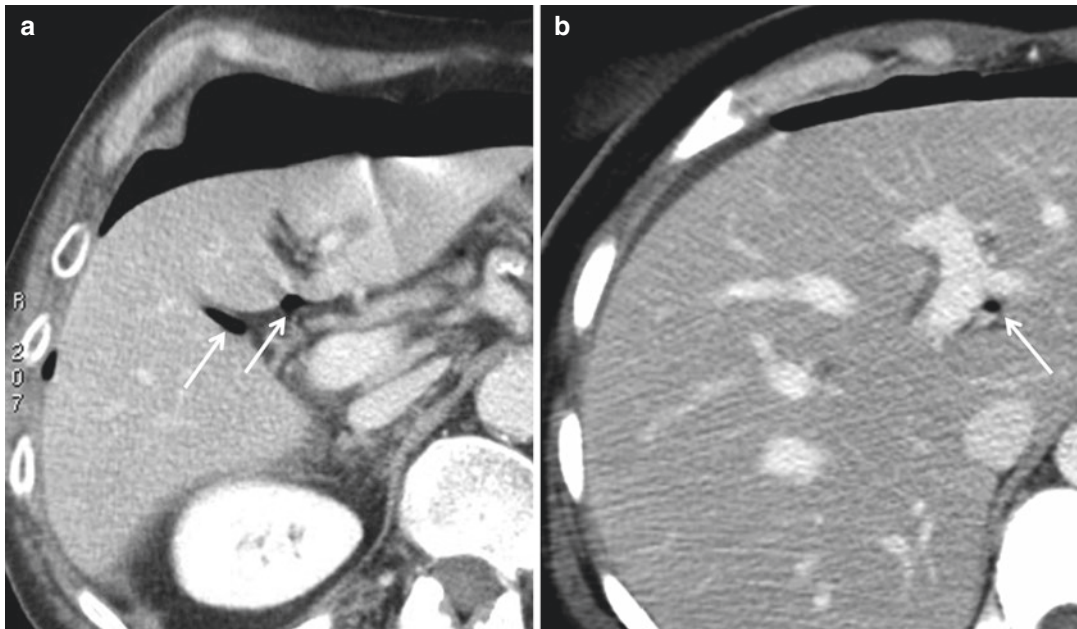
Axial CT scans show air foci at the porta hepatis (arrows) (a). Axial CT scans show focal air bubble collecting in the portal venous system (arrow) (b)
